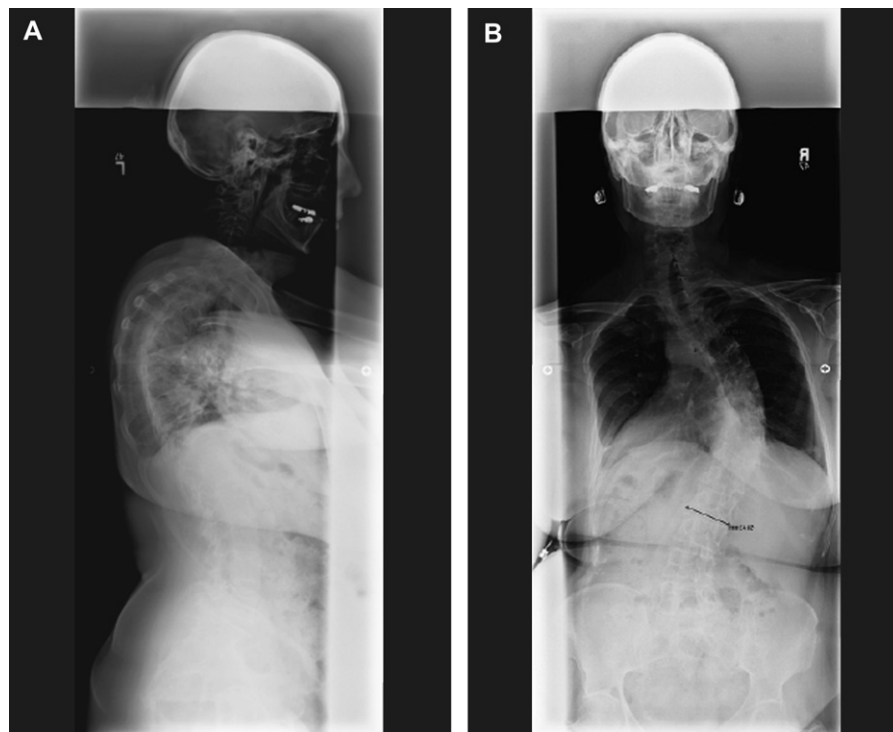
(Top) Preoperative lateral scoliosis X-ray. (Bottom) Preoperative anteroposterior scoliosis X-ray.
